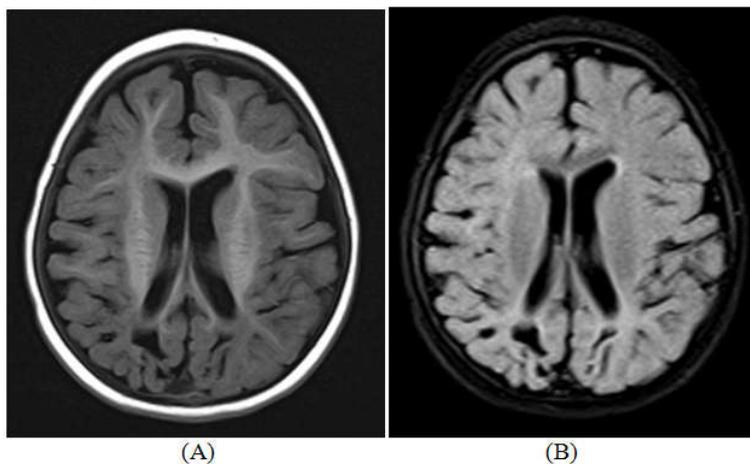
Periventricular leucomalacia with cystic encephalomalacia (A) T1WI, axial (B) FLAIR, axial
